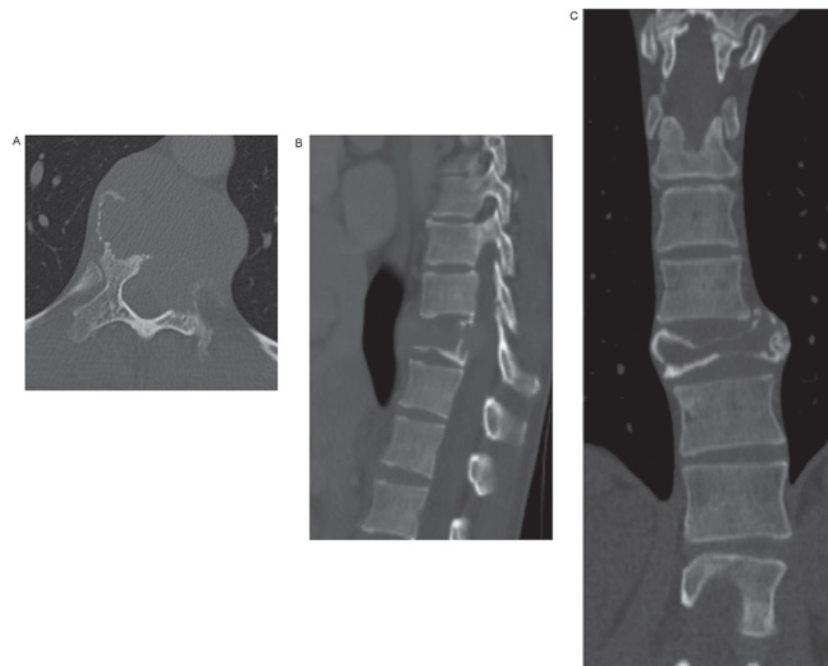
Computed tomography prior to denosumab treatment. (A) Axial view. (B) Sagittal view. (C) Coronal view. An osteolytic lesion involved the T11 vertebral body, which collapsed and expanded into the surrounding soft tissue.
